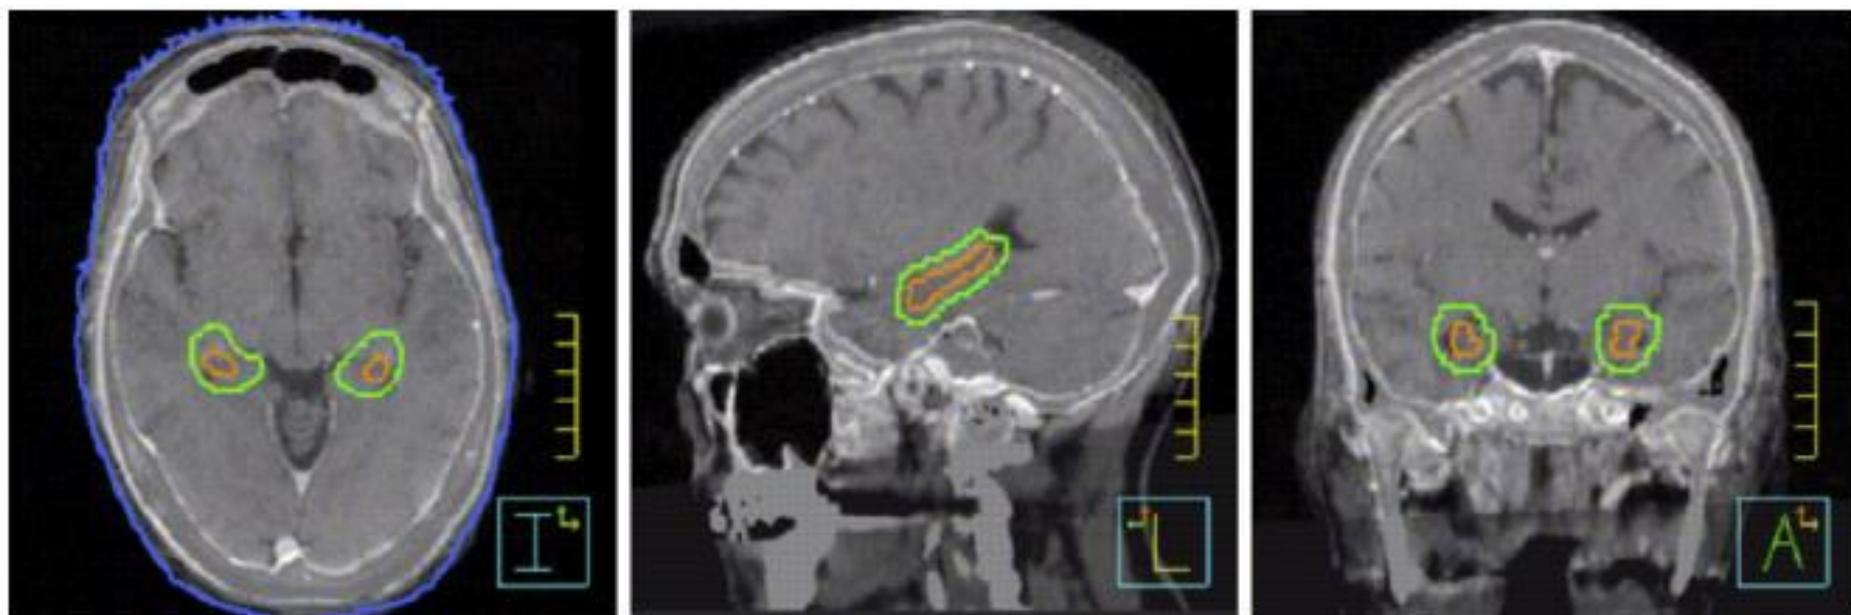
Hippocampal avoidance region. The hippocampal avoidance region (green) was generated by expanding the hippocampal contour (orange) by 5 mm volumetrically to account for setup error. Appropriate anatomical contouring was confirmed using T1-weighted magnetic resonance imaging (MRI) sagittal and coronal sequences.
